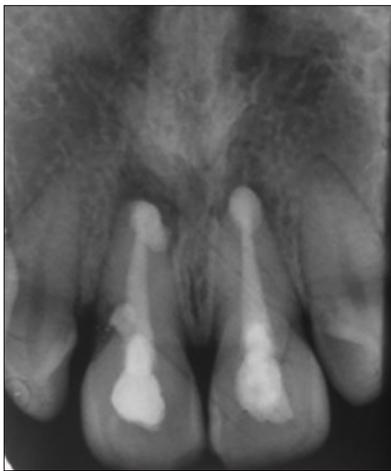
Follow up radiograph at 3 months
